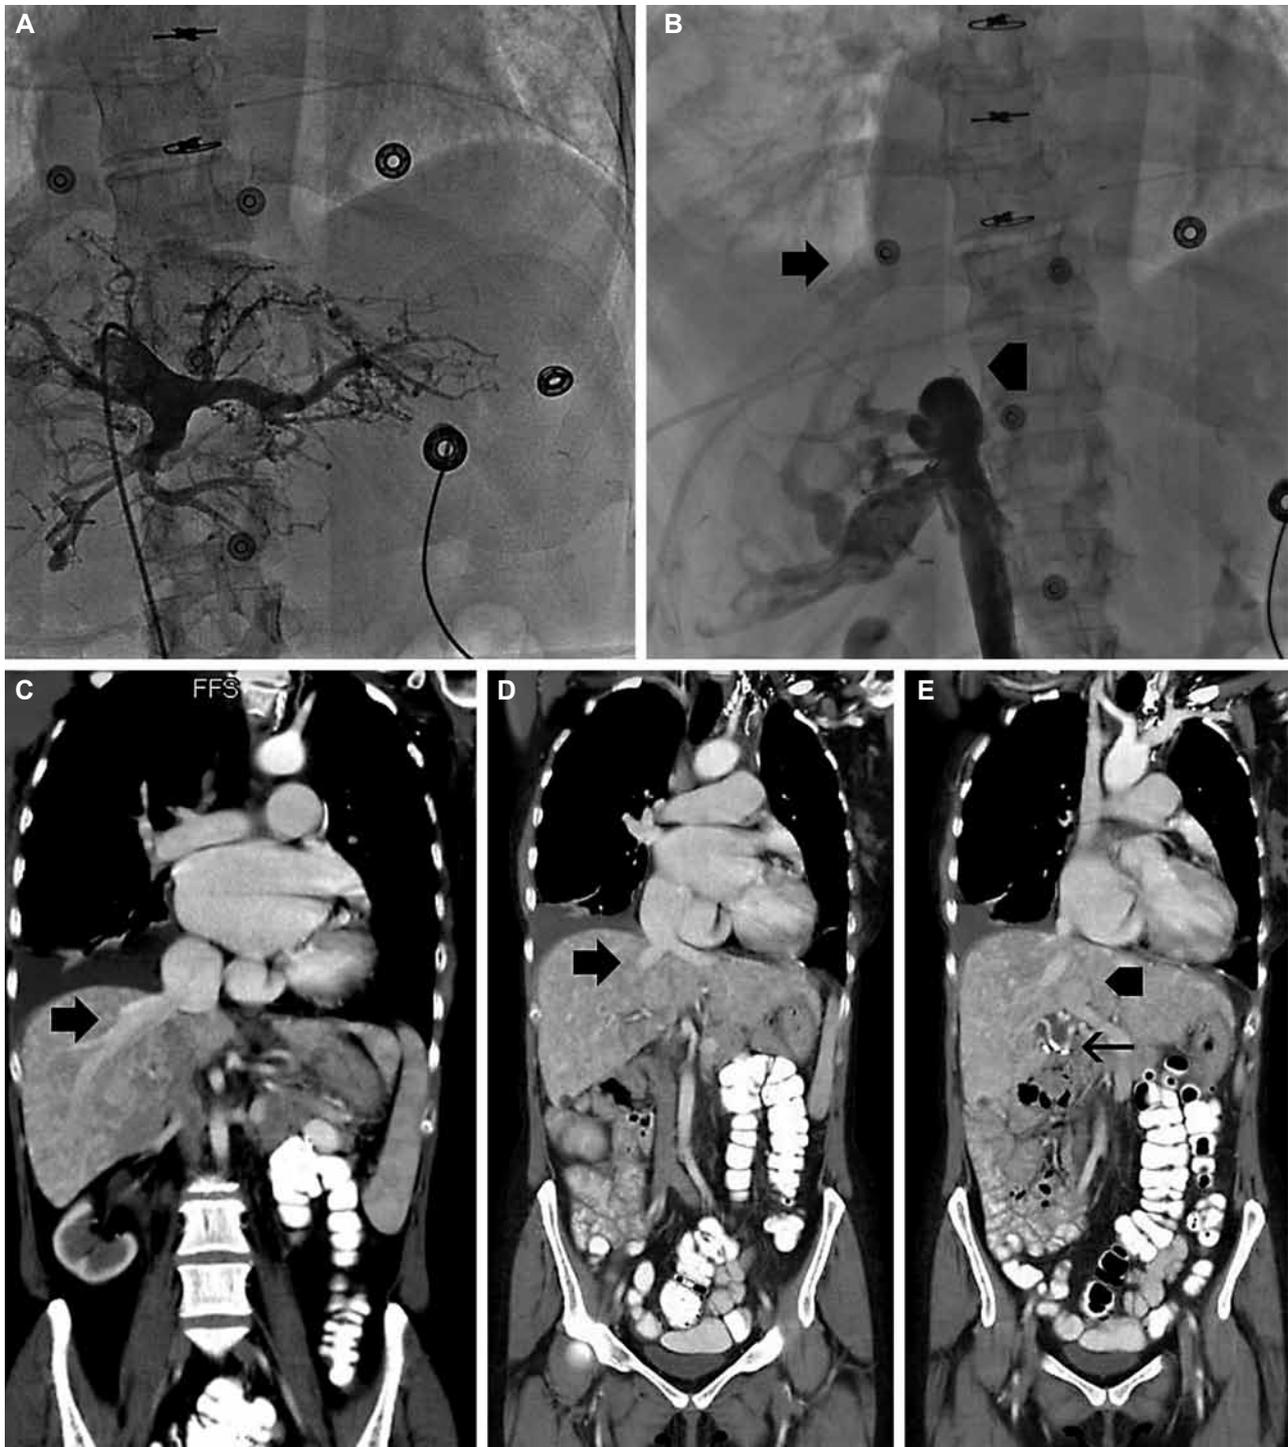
A. The venous portion of a large hepatic arteriovenous malformation (AVM) is back-filled by a selective contrast injection through a pigtail catheter advanced to the inferior *vena cava* (IVC). B. Contrast injection to the femoral vein sheath fills the IVC and extensive hepatic collaterals, which bypass the hepatic IVC segment and empty into the right atrium (RA) (arrow). The IVC itself is interrupted (arrowhead) above the AVM. C-E. coronal reconstruction of a contrast CT scan showing the intrahepatic venous collaterals (arrowhead) opening into the RA and the tortuous vessels of the arterial portion of the AVM (thin arrow). The portal vein (thick arrow) is labeled in E. Note the large bowel malrotation.
